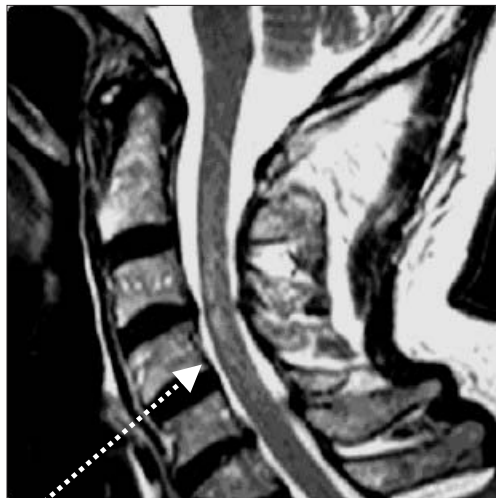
MRI, showing increased cord signal (the "whiter zone") at C3-C4 (arrow) and above.
